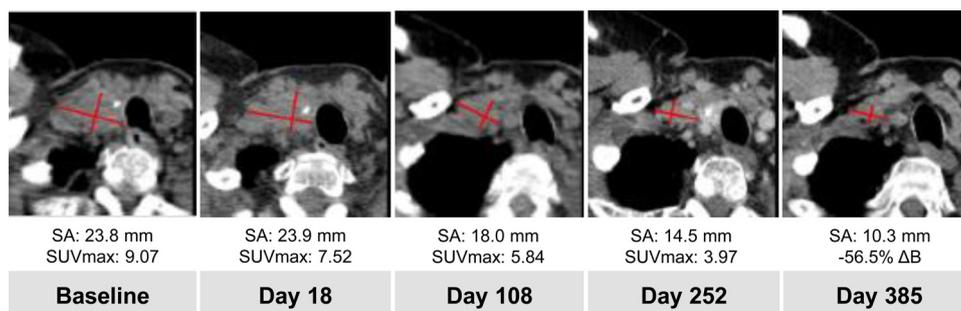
CT scans at baseline and at treatment follow-up. Numbers indicate the diameter of the short axis (SA) and maximum standardized uptake value (SUVmax) of the single hottest lesion. ΔB : change in size of the short axis compared to baseline.
